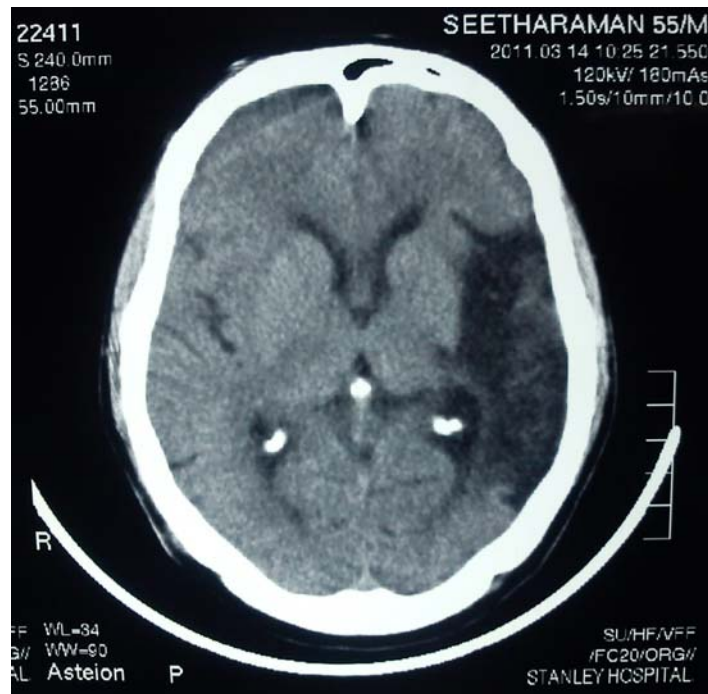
CT Scan (plain) of a 35 years old patient having right hemiplegia with global aphasia with seizures.
